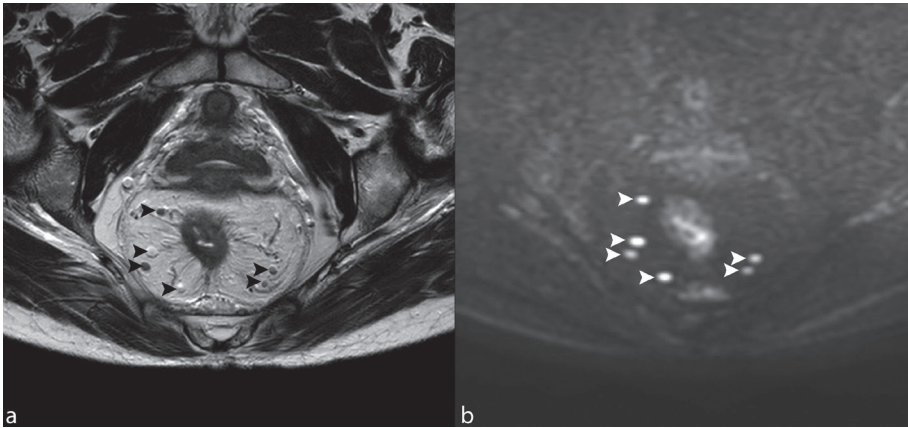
Pre-treatment, primary staging T2-weighted (a) and DWI b1000 s/mm² (b) images of a female patient with a spiculated tumour in the mid-rectum. Note how the various mesorectal lymph nodes (arrowheads) are very easily detectable on DWI.
